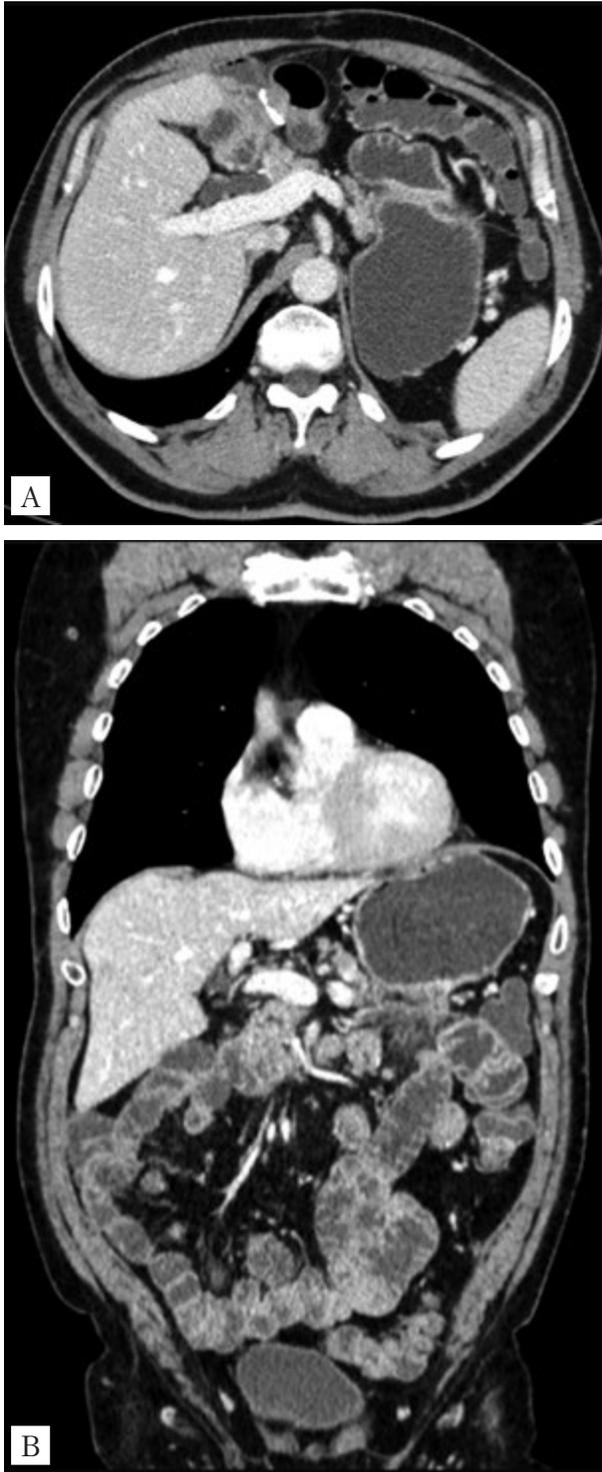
CT scan of the abdominal cavity with contrast, as of October 10, 2024: axial (A) and frontal (B) projection. There are no signs of prolongatio morbi
